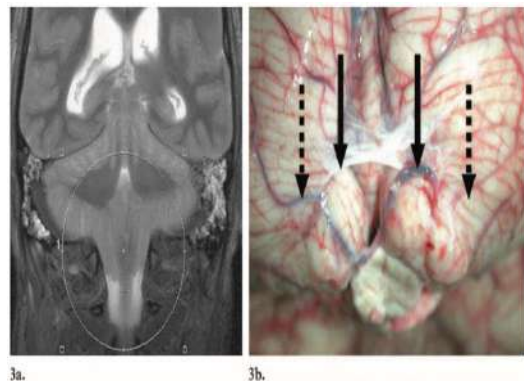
Comparison between virtopsy and autopsy of a image of a case where increased intracranial pressure is the cause of death. (a) MR image shows the herniation of the basilar parts of the cerebellum into the foramen magnum. (b) Autopsy shows the cerebellum with swelling of tonsils (shown by the solid arrows) and a pressure mark caused by the foramen magnum (shown by the dotted arrows) [15].
